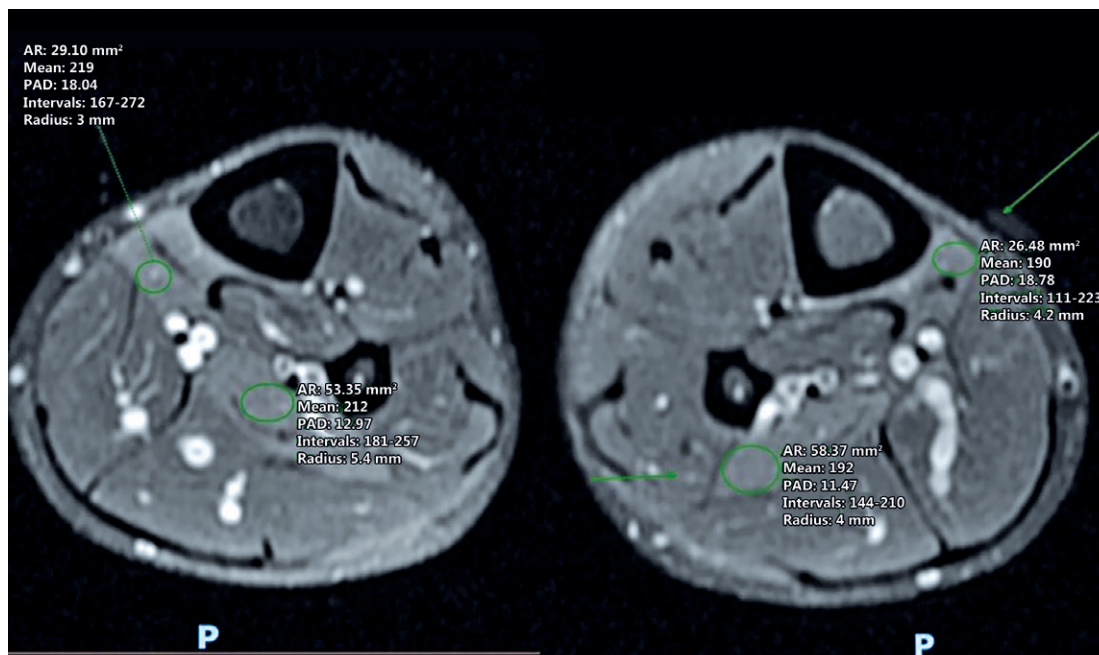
Patient T2-weighted, post-effort MRI image showing increased volume and signal.
